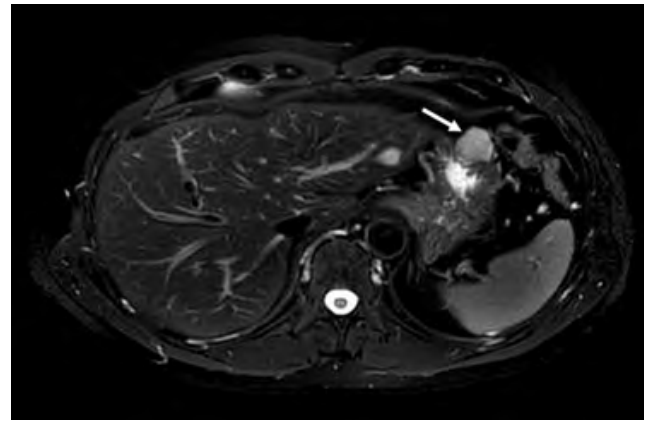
Magnetic resonance imaging (T2 weighted MRI). Tumour of the anterior gastric wall (white arrowhead).
